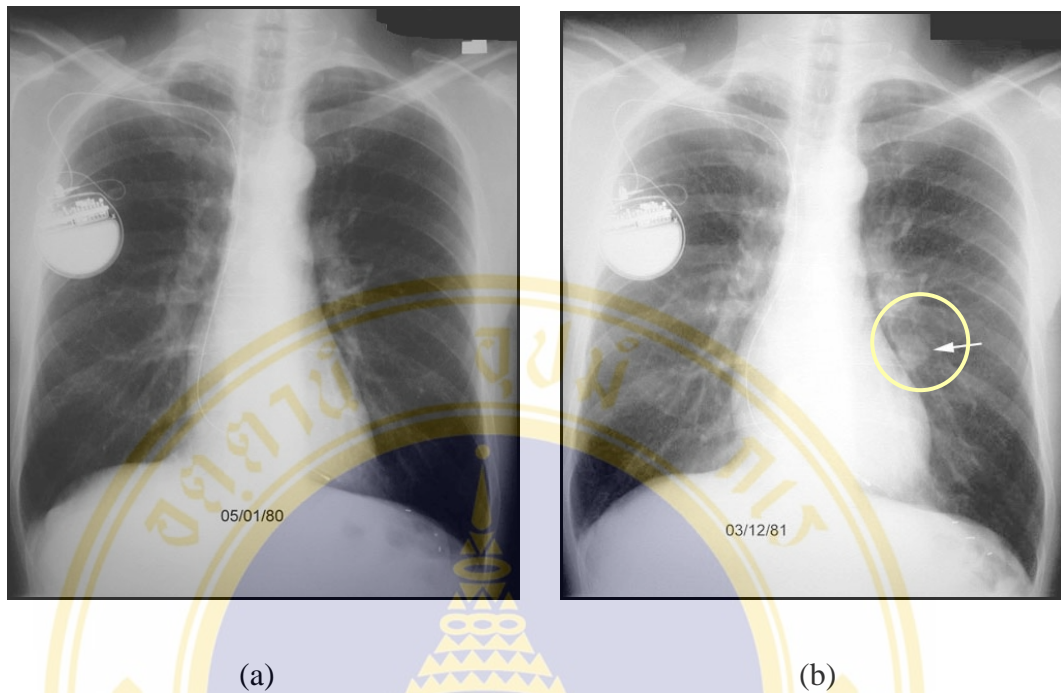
Chest x-rays showed doubling time of lung cancer
